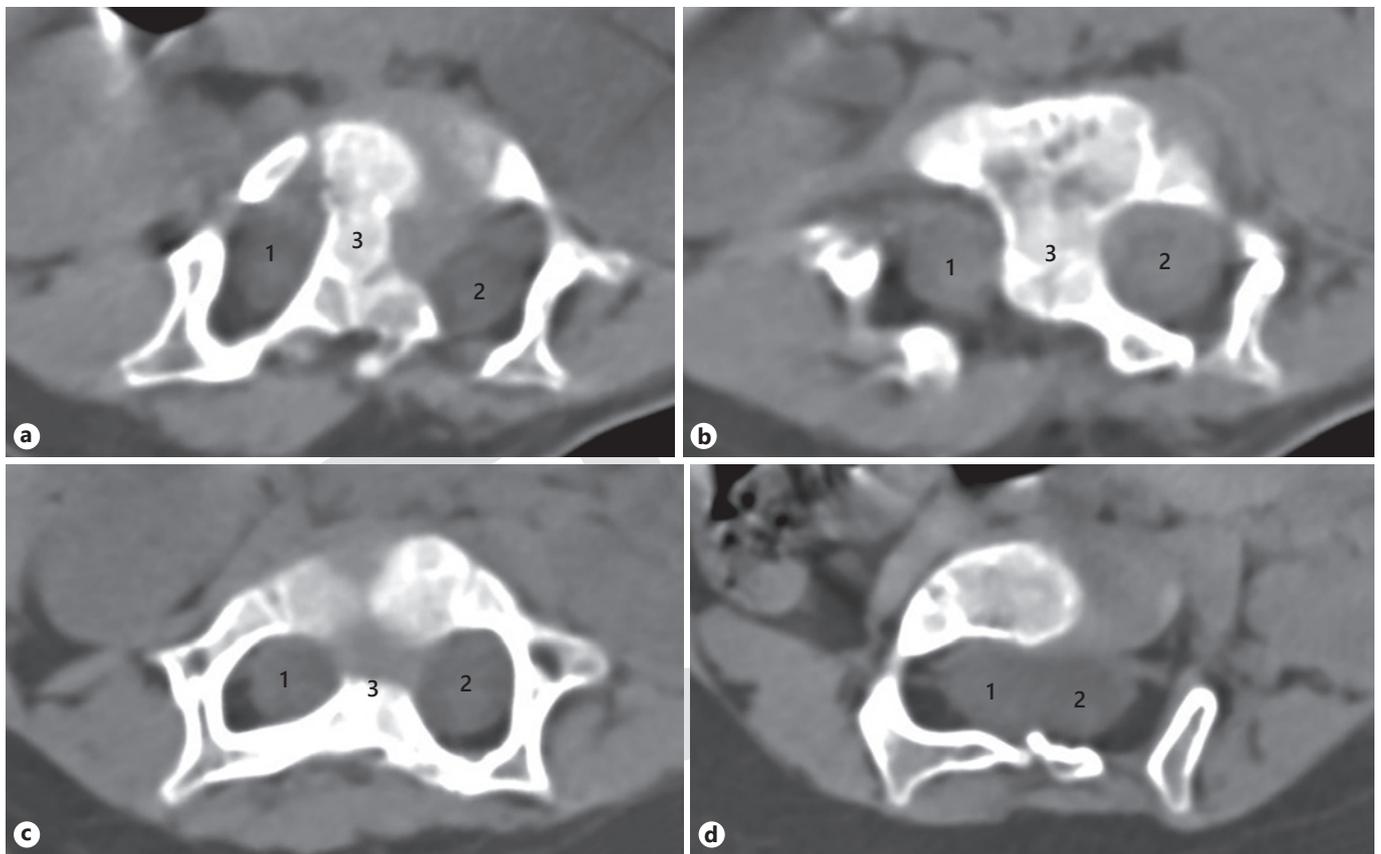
Split spinal cord (1 and 2) with a large bony septum (3) on axial CT scans (a–d).
